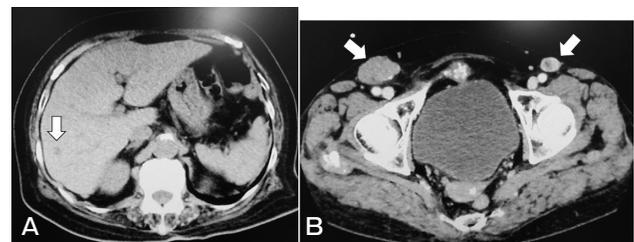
Computed tomography (CT) with axial views of abdomen (A) and groin (B) at 2 months after the PET-CT scan. CT showed one small metastatic lesion in the liver (A) and swollen inguinal lymph nodes on both sides (B), as indicated by the white arrows.
